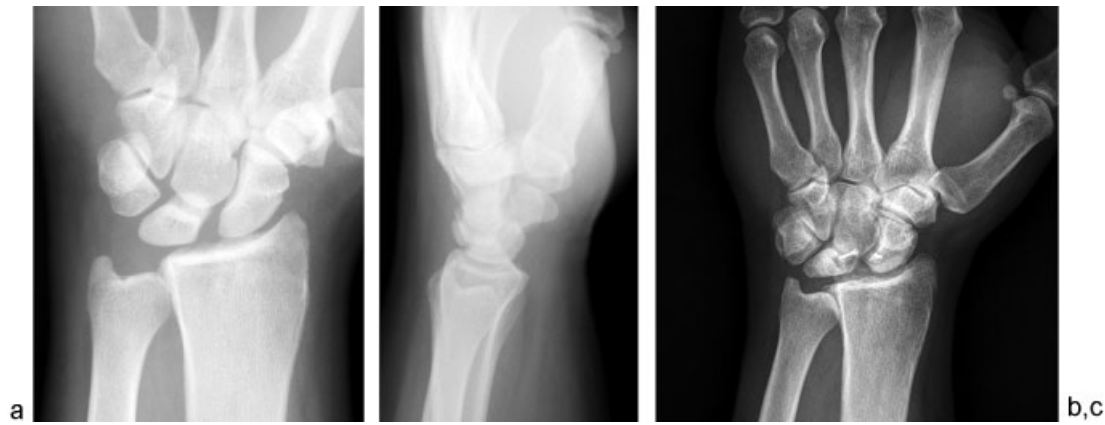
(a,b) AP and lateral radiographs of wrist 9 demonstrating SL instability before capitolunate BLB procedure. (c) AP radiograph of wrist 9 at 54 months after original procedure, demonstrating screw migration and development of SLAC arthritis.
